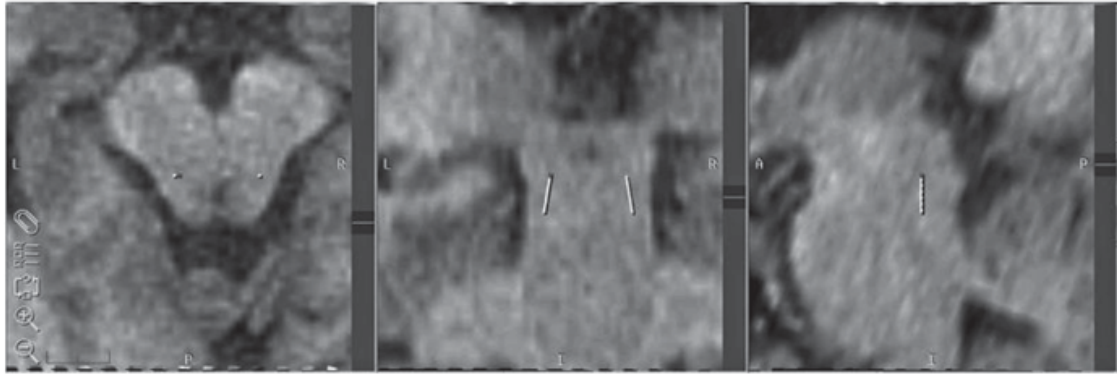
The MRI location of the PPN. T1-weighted MR images from planning software showing the atlas-based localization of PPN in horizontal, coronal and sagittal (from *left to right*) planes. (Reproduced with kind permission from Zrinzo et al. 2008)
